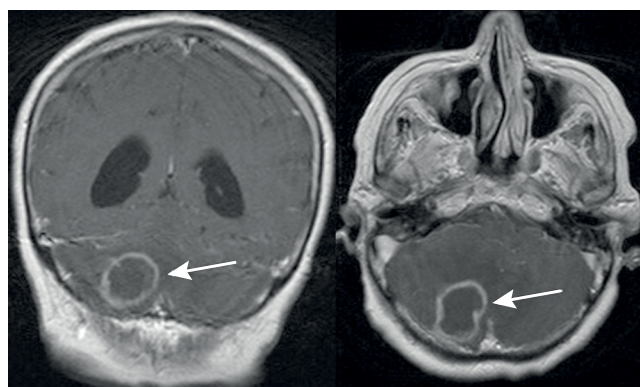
Brain MRI shows an expansive lesion with gadolinium enhancement in the cerebellum. Biopsy confirmed central nervous system post-transplant lymphoproliferative disorders (PTLD).
